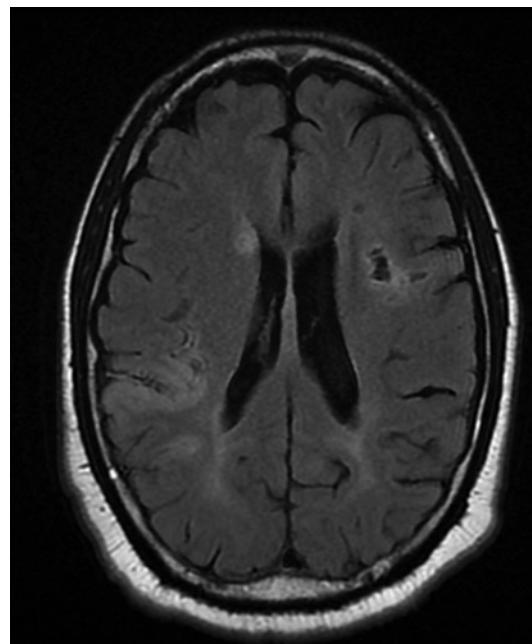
MRI brain obtained 2 months after initial MRI showing worsening of stroke burden.
